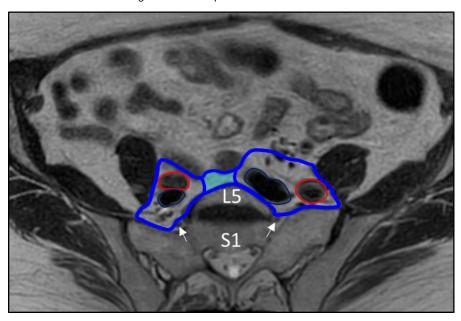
Delineation of common iliac regions as part of the CTV-E on axial T2w FSE MRI. Common iliac artery (red) and vein (dark blue) are indicated. Combined contour (blue) is created by joining the common iliac regions of both sides in front of the lumbar vertebra (marked with transparent cyan subaortic inter-iliac region). Bowel loops and sacral nerve roots (arrows) are excluded from the contour. The area behind the vessels between the vertebra and the psoas muscle is included.
